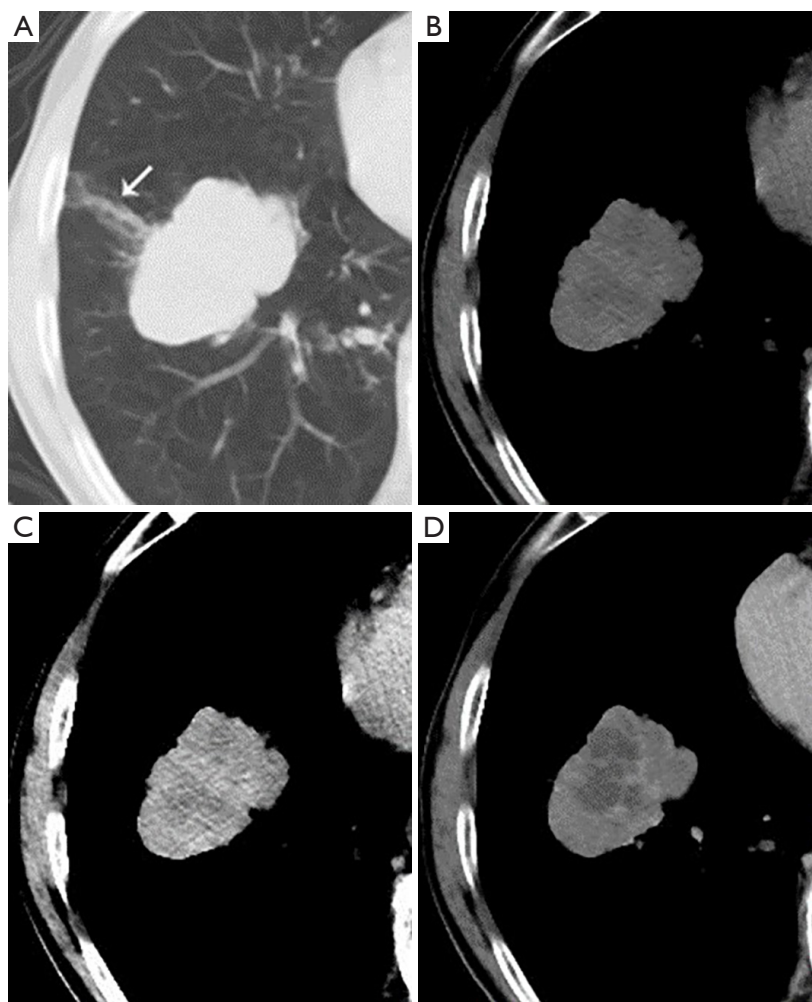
CT images of a malignant lesion. The plain CT scan shows a lobulated and well-defined mass with a beam-shaped opacity (white arrow) in the right lower lobe (A); and multiple ill-defined focal areas with slightly lower attenuation are detected in the mass on standard and narrow mediastinal window (B,C). Multiple, partially ill-defined, and irregular HyS with Δ CT of 10.2 HU can be observed on the contrast-enhanced image (D). Δ CT = peak CT value measured on enhanced images – CT value measured on plain CT scan. CT, computed tomography; HyS, hypodense sign; HU, Hounsfield units.
